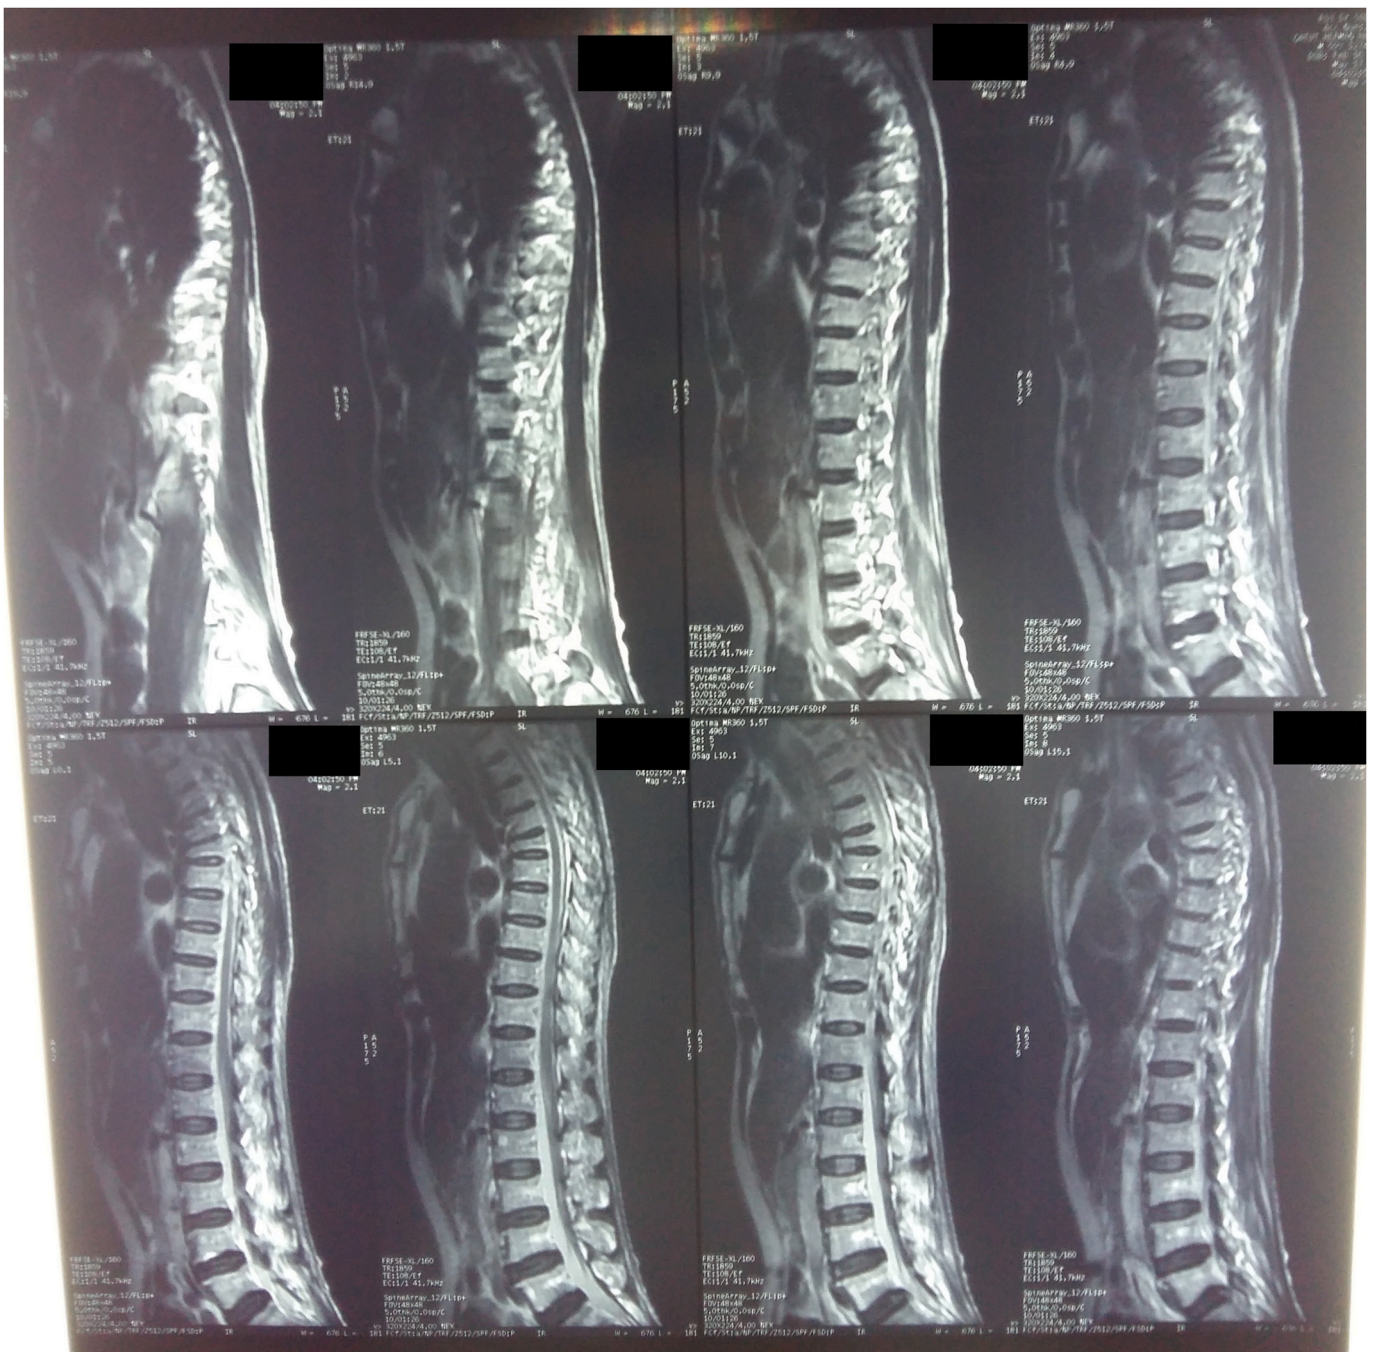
Contrast thoracolumbar MRI shows wedge fracture of the 6th thoracic vertebrae.
